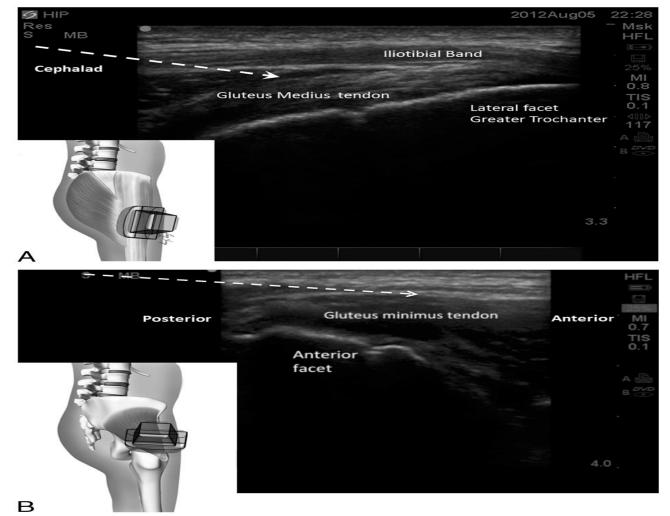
A, Ultrasonography shows the target for the peritendinous injection for gluteus medius. The dashed arrow shows the path of the needle inserted in-plane from cephalad to caudal direction. The insert shows the ultrasound probe position. B, Ultrasonography shows the target for the peritendinous injection for gluteus minimus. The dashed arrow shows the path of the needle in plane from posterior to anterior direction. The insert shows the ultrasound probe position. Reproduced with permission from Ultrasound for Regional Anesthesia, www.usra.ca.
